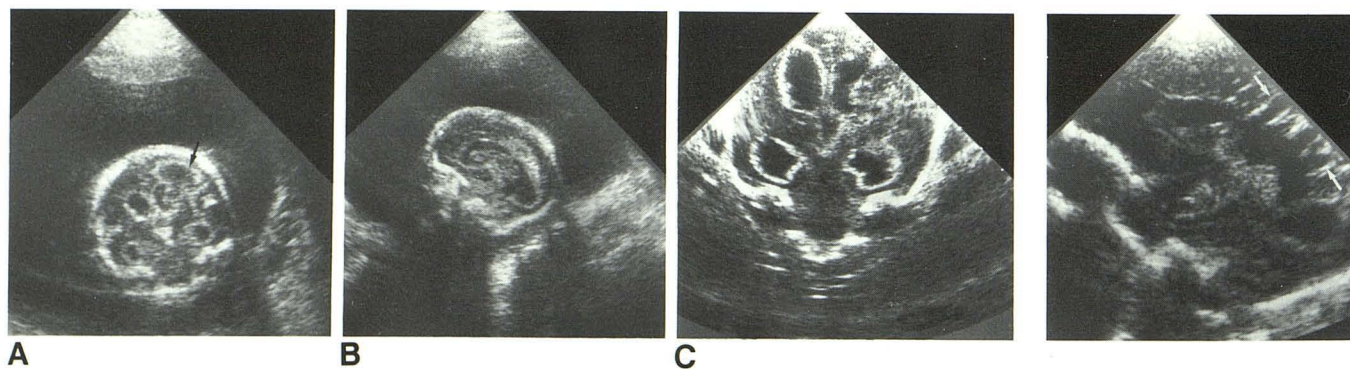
A-B, Recipient twin. In utero coronal (A) and sagittal (B) sonograms show ventricular dilatation with intraparenchymal extension of hemorrhage (arrow).
